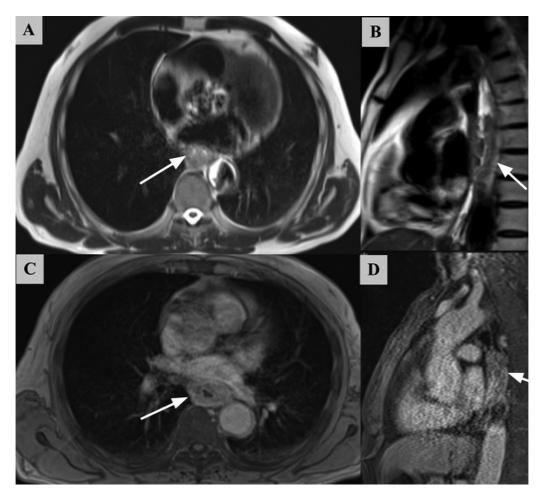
Magnetic resonance imaging (MRI) in esophageal cancer. Axial and sagittal precontrast T2-weighted and postcontrast T1-weighted images shows heterogeneous circumferential mural thickening of the middle thoracic esophagus (arrows, A and B) which shows heterogeneous enhancement on postcontrast images (arrows, C and D).
